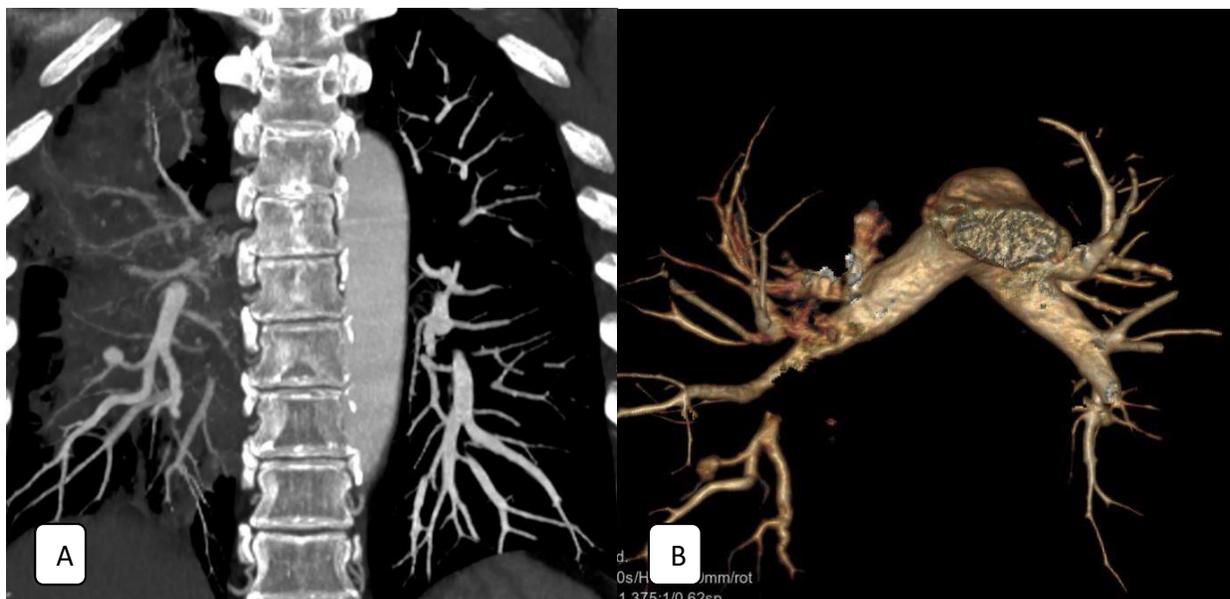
(A) CT coronal image shows pseudoaneurysm in right lower lobe pulmonary artery
